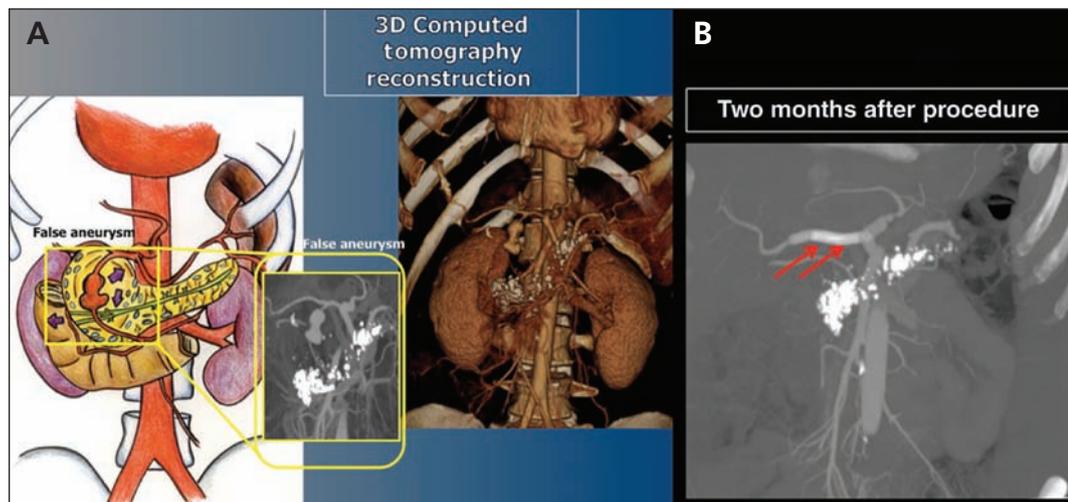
(A) Descriptive image and contrast-enhanced computed tomography showing bleeding false aneurysms that had developed over a pancreatic pseudocyst and are surrounded by multiple pancreatic calcifications. (B) Shrinkage of the false aneurysm and stent patency (arrows) after endovascular exclusion.
